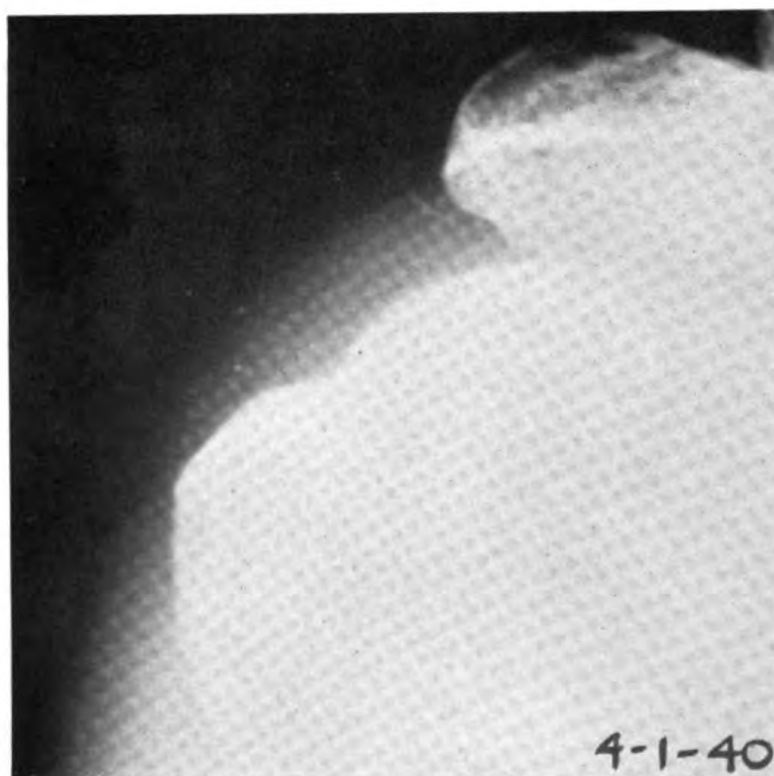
CASE 20.—TWO WEEKS AFTER THE SECOND COURSE OF 300 ROENTGENS.
